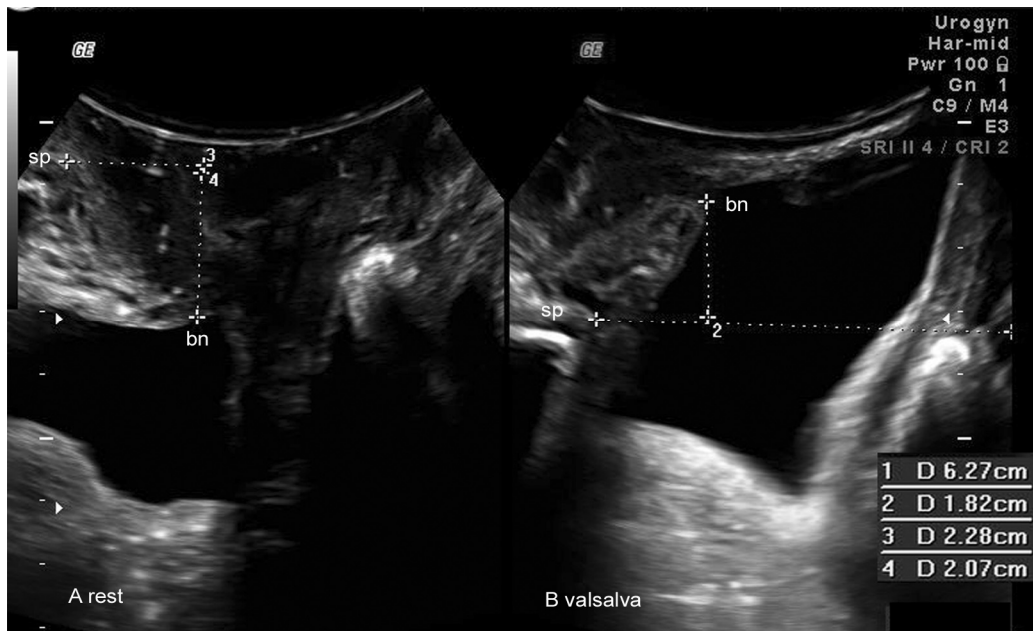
Marked bladder neck descent as shown on sonography, A at rest and B on on maximum valsalva. Horizontal bladder neck descent is 39.1 mm, (20.7 (rest) – (-18.2 (Valsalva)), = 39.1 mm).
